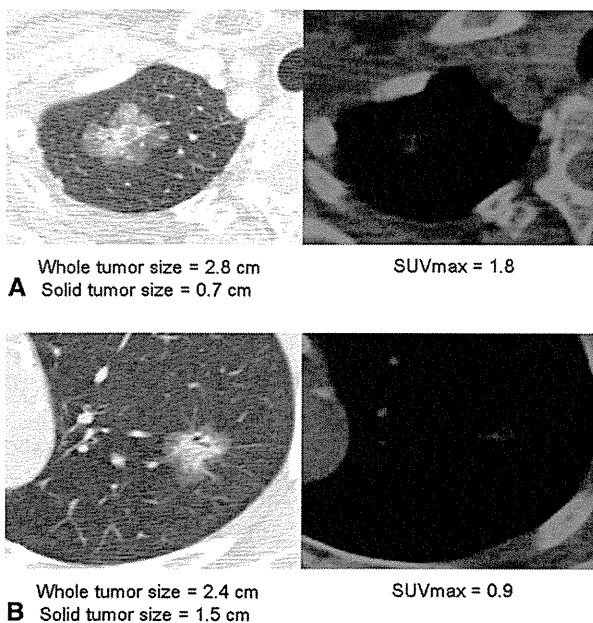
Examples of tumors larger than 2 cm that met the predictive criteria of pathologic node negative. A, Whole tumor size, 2.8 cm; solid tumor size, 0.7 cm; maximum standardized uptake value (SUVmax), 1.8. This tumor can be treated with sublobar resection, such as right apical segmentectomy. B, Whole tumor size, 2.6 cm; solid tumor size, 1.7 cm; SUVmax, 0.9. This tumor can be treated with sublobar resection, such as left apico-posterior segmentectomy.
